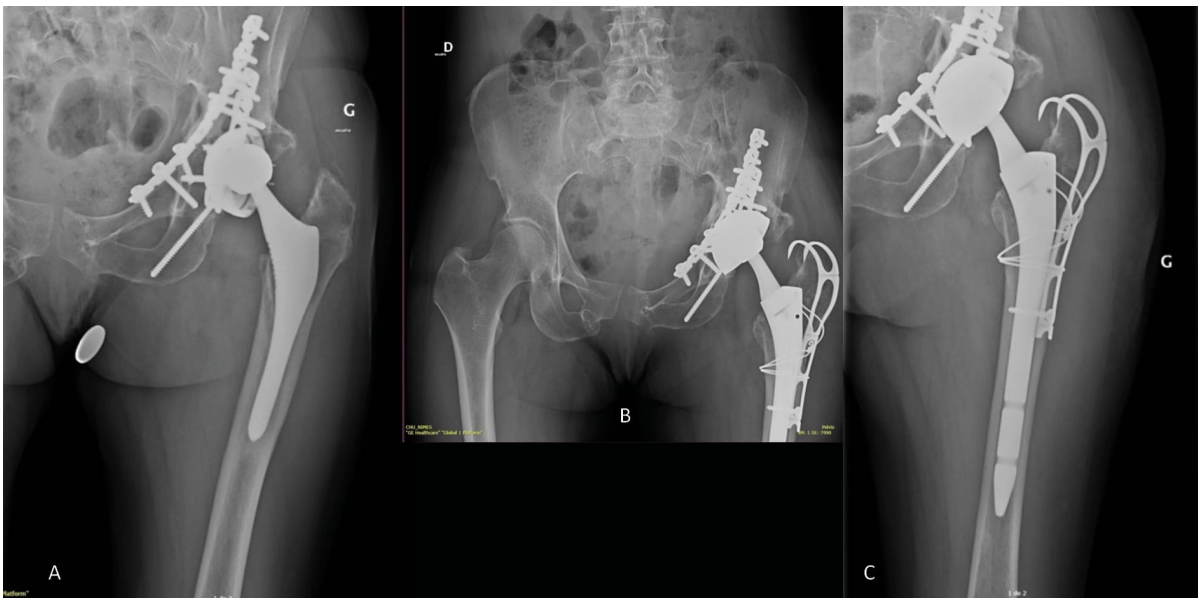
Mrs M., a 51-year-old with a history of complex acetabular fracture treated using an ilioinguinal incision (stabilisation of the anterior column) and Kocher-Langenbeck approach (internal fixation of the column of the posterior wall). Course involved stage 4 avascular necrosis of the femoral head, which was operated on after 1 year by THA (4A). Progressed to loosening and migration of the cup (4B). Radiolucent line at the femur–component interface in Gruen zone 7 with atrophy of the calcar femorale. Perioperative observation: metallosis and corrosion of the morse taper, resulting in the decision for bipolar revision, greater trochanter weakened by osteolysis. Perfect stem osteointegration. Femoral window via extended trochanteric osteotomy (ETO). Cup revised with a cementless DM cup with spikes (4C). Good implant stability perioperatively. Femur revised with a modular locking revision stem. Plating and cerclage wire. Repeat radiography two years postoperatively.
